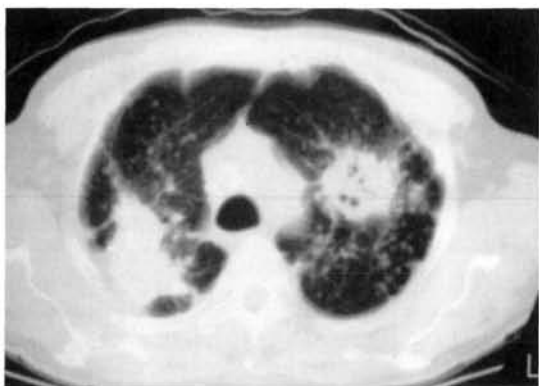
CT scan of the same patient
